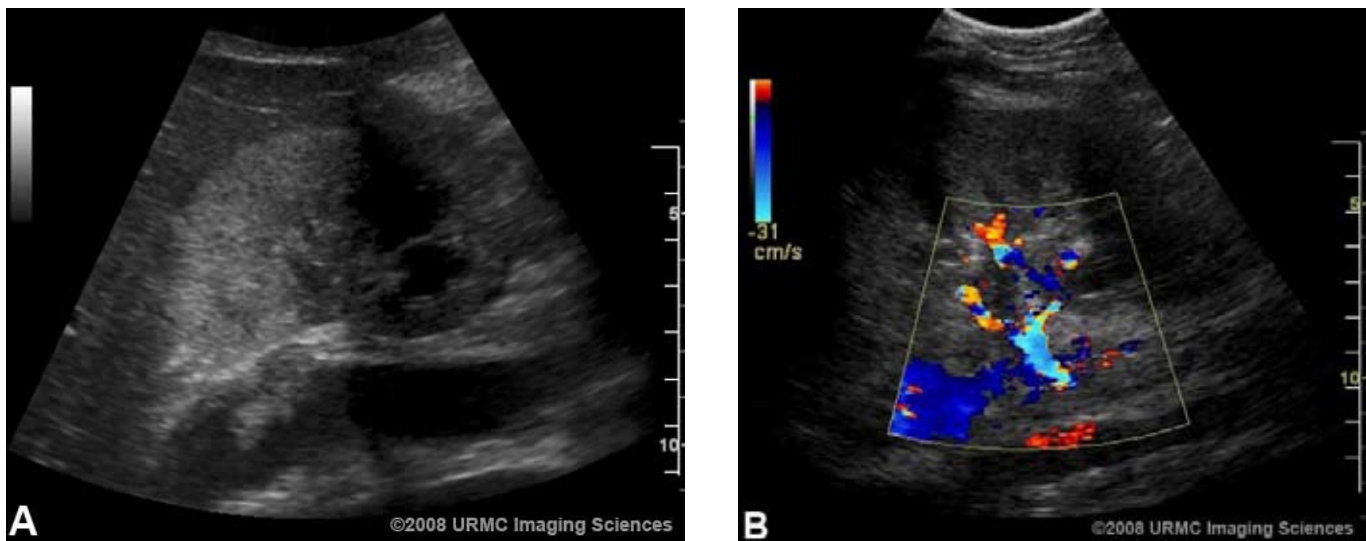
Longitudinal grayscale (A) and color flow Doppler (B) images of the right kidney demonstrates a hyperechoic thrombus extending from the superior renal vein into the IVC.
